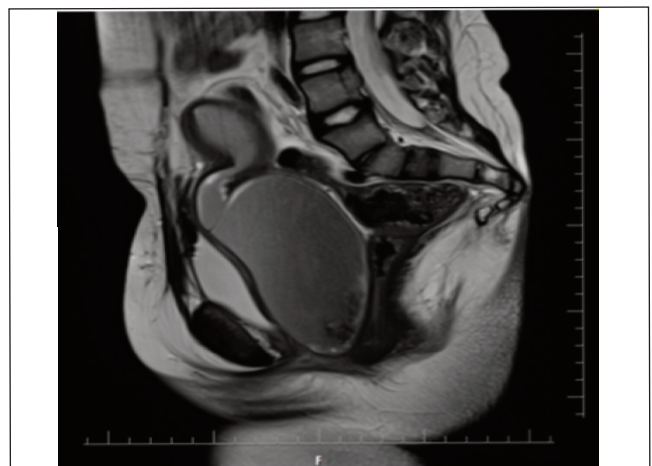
MRI pelvis with contrast showing an elongated and distended vagina with central haemorrhage displacing the uterus and urinary bladder as well as haemorrhage in the endometrial canal suggestive of haematometrocolpos.
